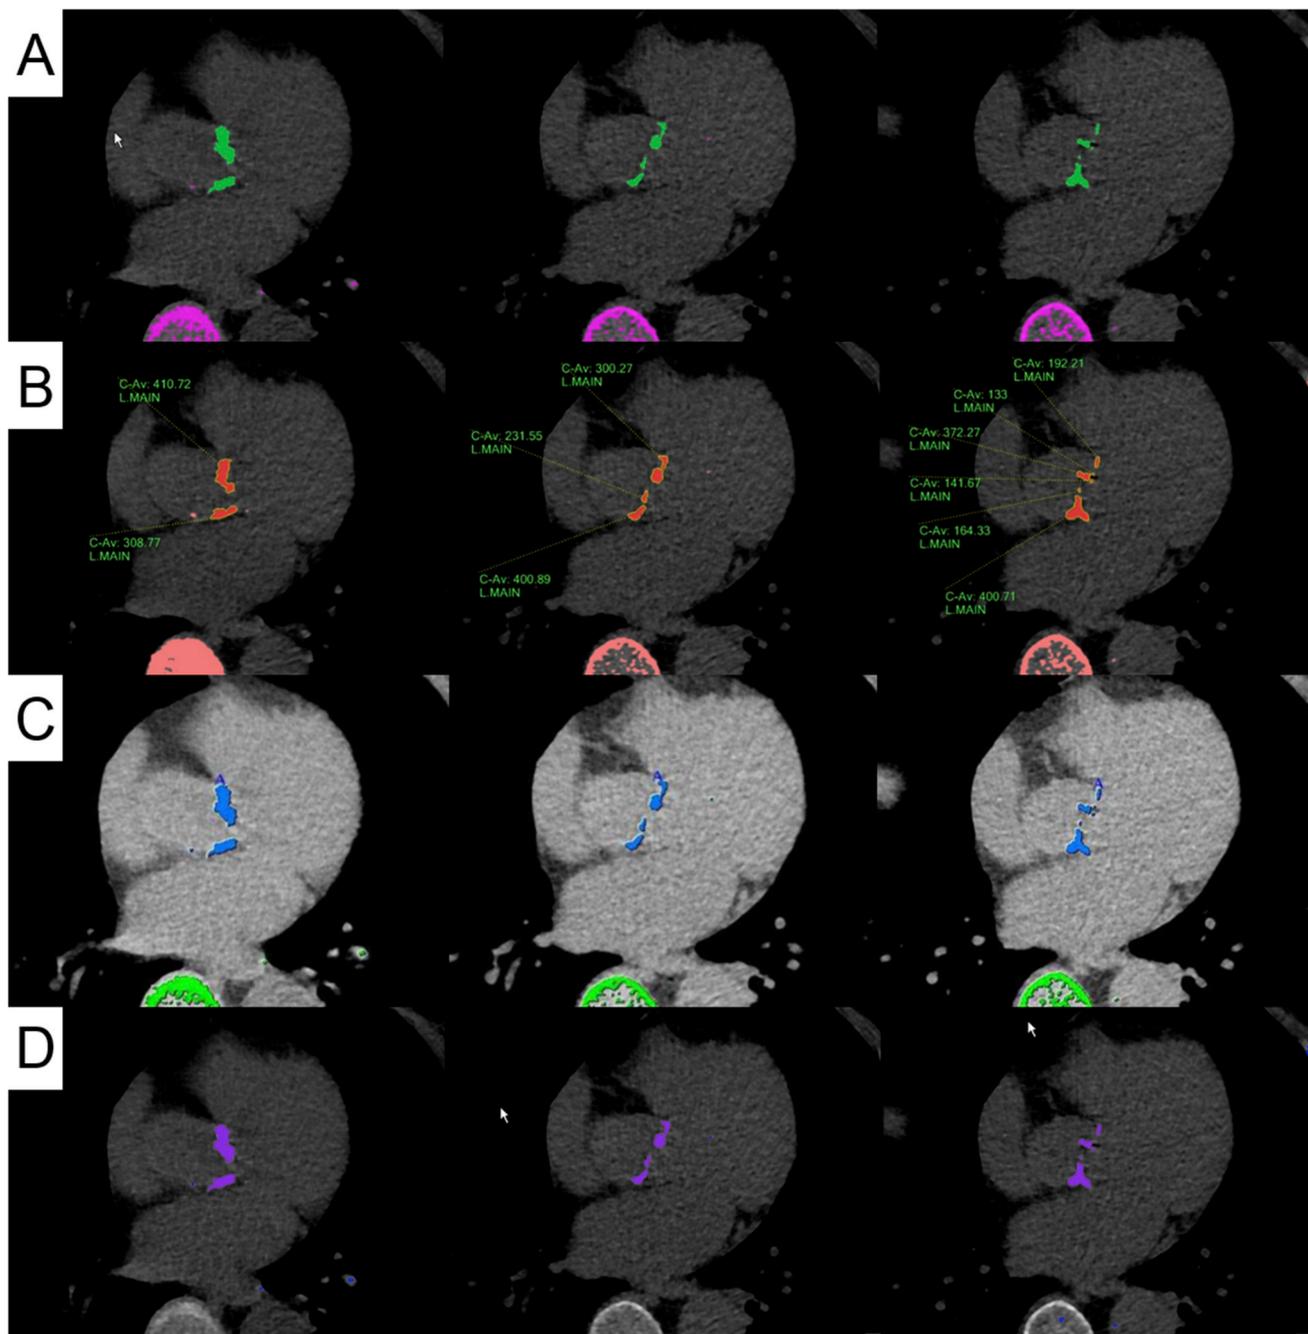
Representative images of a 90-year-old male patient with severe aortic stenosis planned to undergo transcatheter aortic valve implantation. A–D, Transverse CT sections (same slice positions) evaluated with all workstation platforms (A, workstation 1, Siemens; B, workstation 2, Philips; C, workstation 3, GE; D, workstation 4, Pie Medical).
